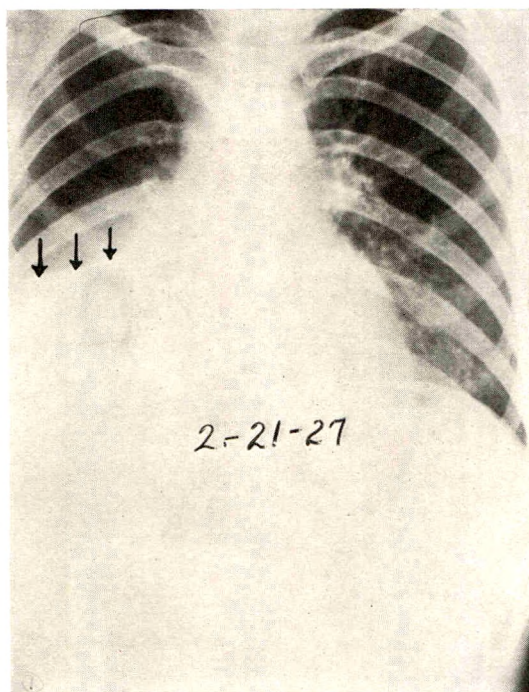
Roentgenogram of Case II taken soon after admission. The right-sided mediastinal empyema assumes a right-angled shape representing the costodiaphragmatic type. Arrows indicate the upper border of the encapsulation. The lower border is spread out over the diaphragm. Note the origin of the fluid from the mediastinal pleura.
